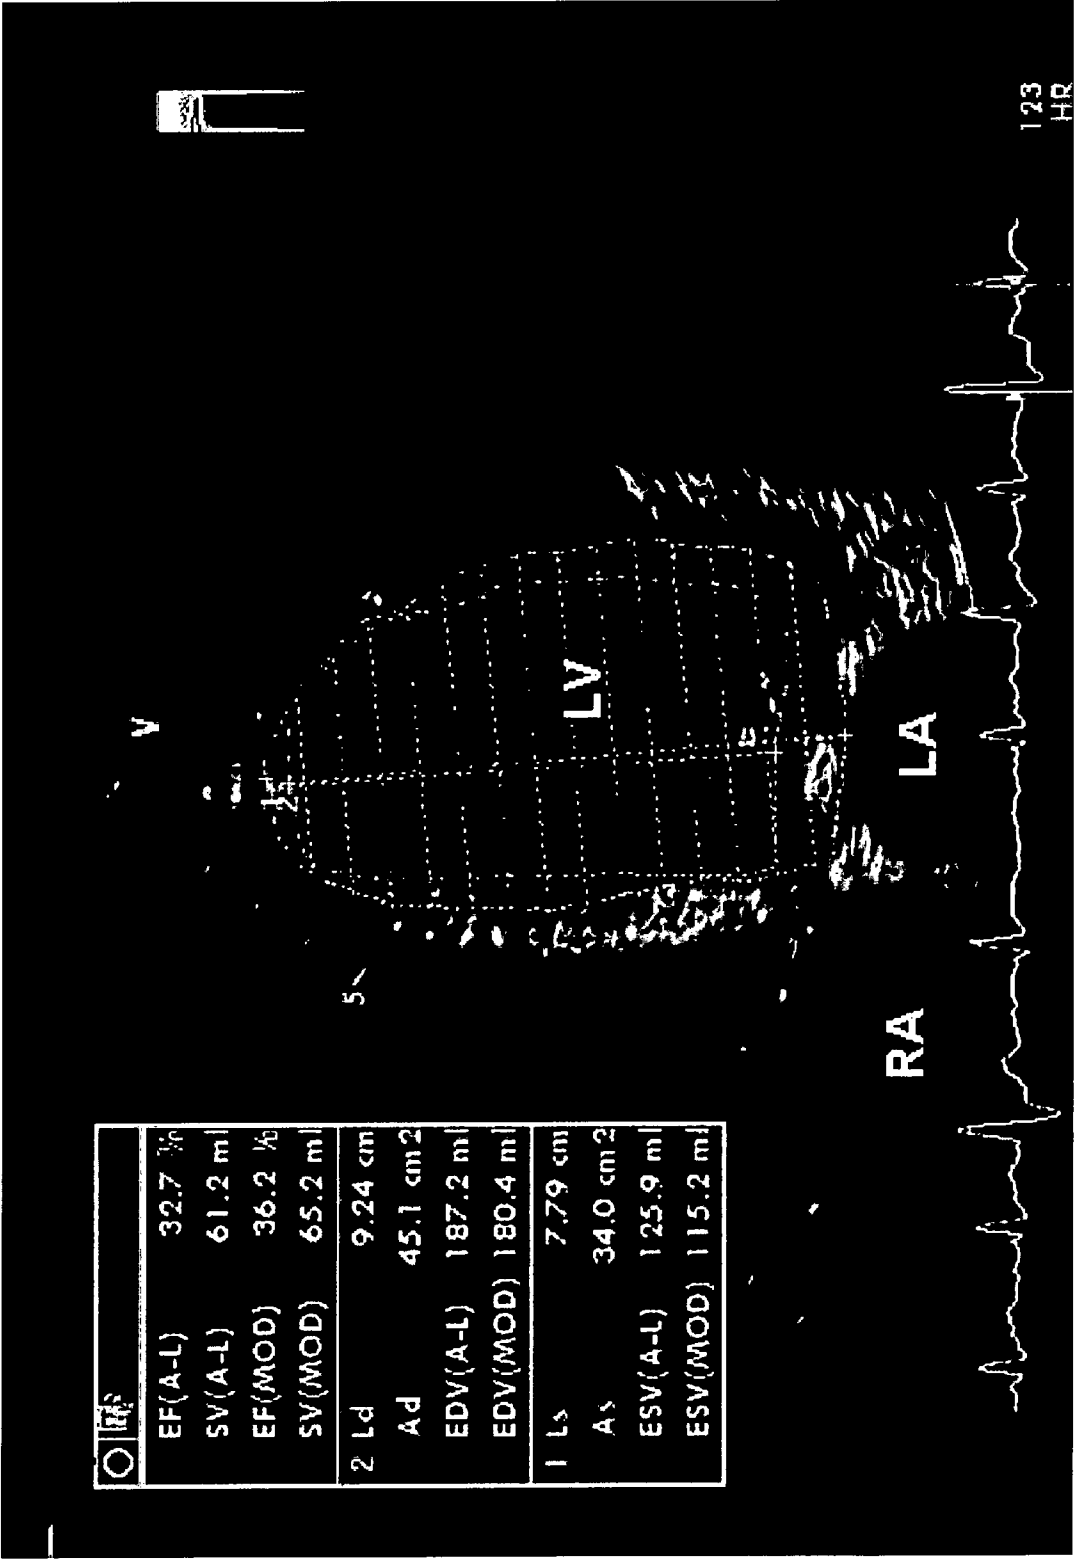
Left ventricular ejection fraction (LVEF) calculated by biplane Simpson's method. This technique requires planimetry of the endocardial border in systole and diastole and assumes ventricular volume is the sum of the volumes of adjacent sets of discs of varying depth and cross-sectional area. This is the most accurate echocardiographic technique for LVEF and was used for all patients in our study.
